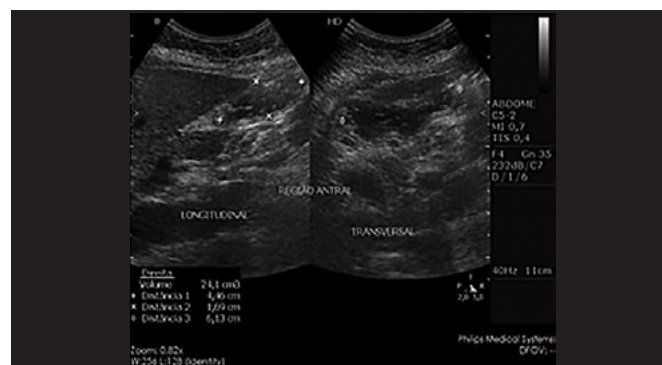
Ultrasound images showing the gastric antrum and methodology for calculation of the residual gastric volume.
